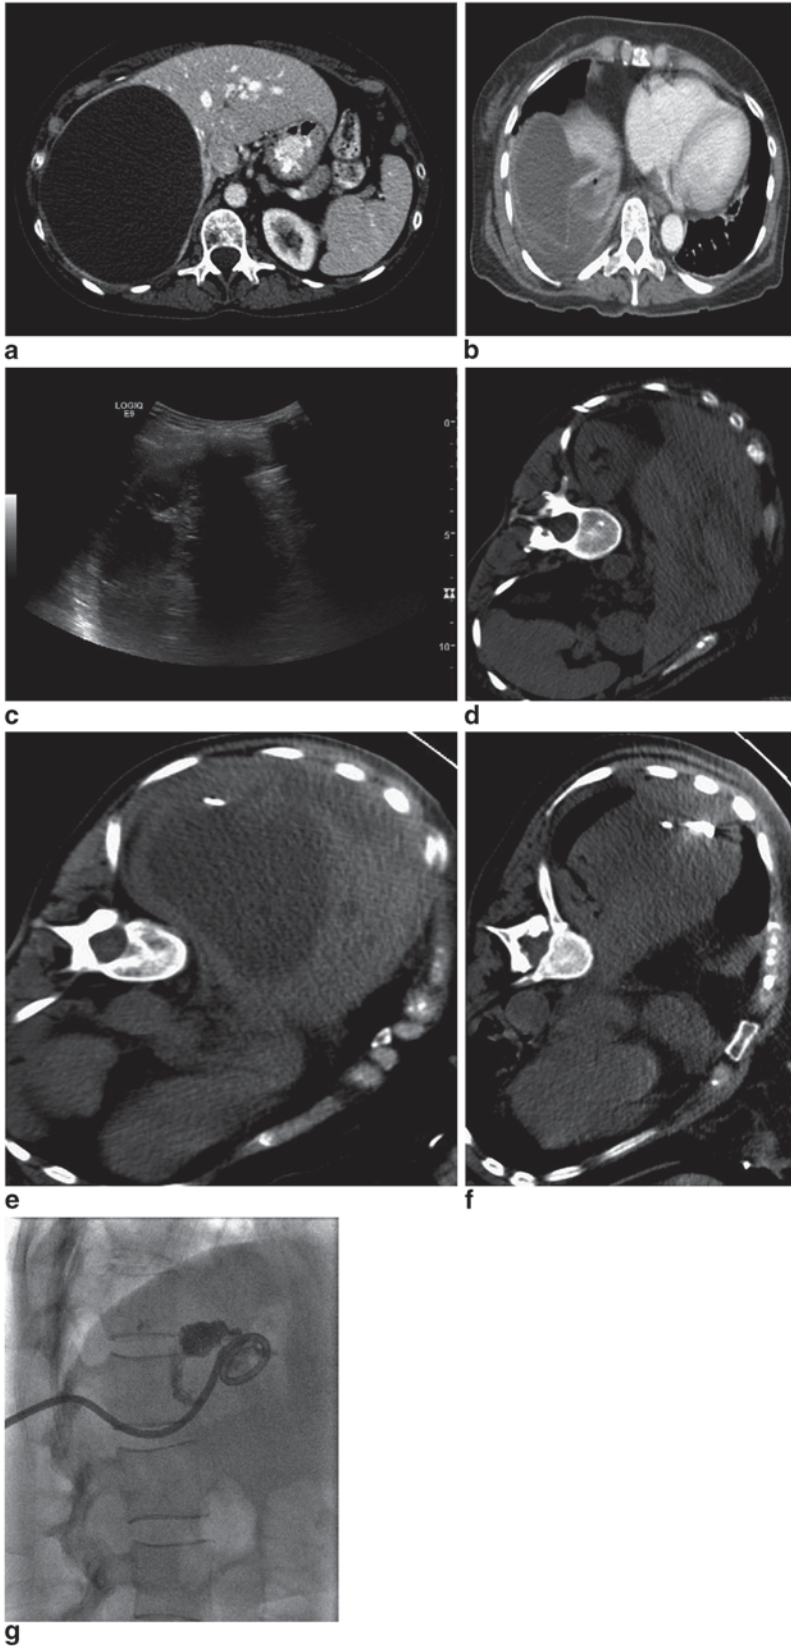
A 67-year-old female presented with a large symptomatic simple appearing cyst ($14.4 \times 11.8 \times 15.9$ cm) in the dome of the liver (a) and underwent laparoscopic cyst wall fenestration and cyst wall fulguration. She was discharged home the next day but presented to the emergency department on postoperative day 7 with worsening right shoulder and flank pain with a leukocytosis of 12.8 K/uL . A CT of the abdomen and pelvis was obtained, which demonstrated a low attenuating fluid collection with a thin rim of peripheral enhancement adjacent to the site of prior laparoscopic cyst fenestration with a small focus of air (b). The fluid collection was accessed via an intercostal approach underneath the 11th rib posteriorly utilizing US guidance through the rib interspaces with aspiration of serosanguinous fluid (c). A limited noncontrast CT performed after placement of the needle under US guidance confirmed appropriate positioning of the needle and due to the concern for an infected collection, a 10 Fr locking loop catheter was placed (d-f). The aspirate grew *Escherichia coli* and the patient was treated with appropriate oral antibiotics. After 2 weeks of active catheter drainage, an abscessogram was performed, which demonstrated no significant residual collection or communication to the biliary system and the catheter was uneventfully removed (g)
